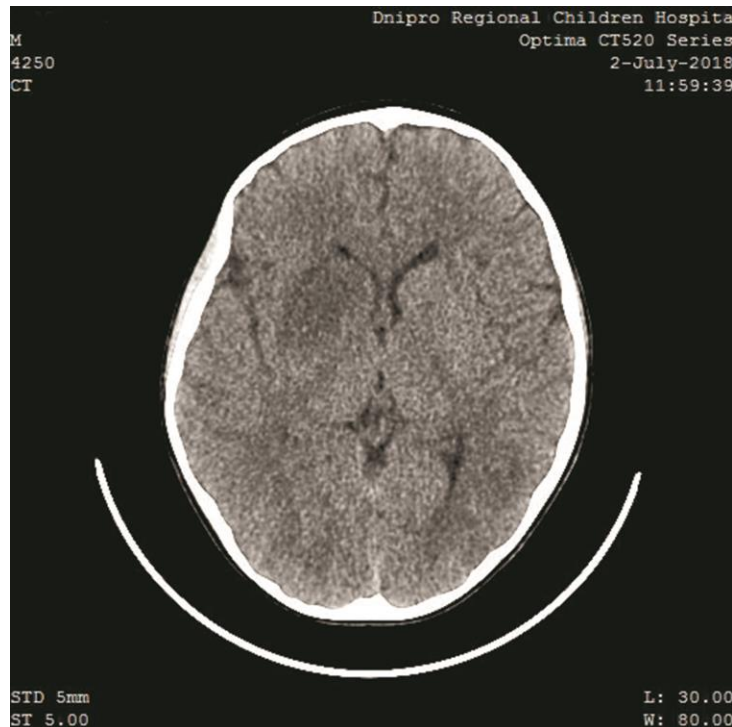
Cerebral CT image: A hypodense lesion in the left posterior temporal area
